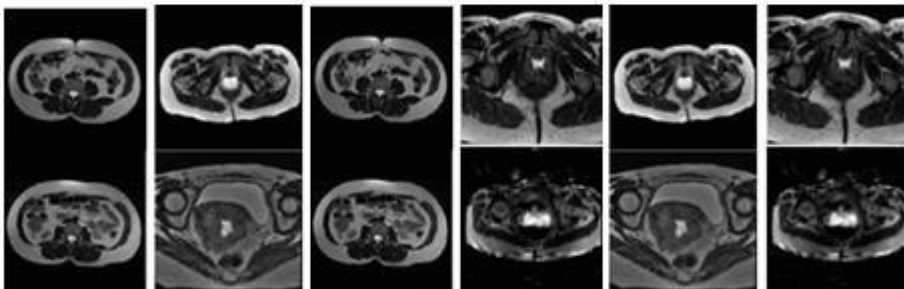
MRI cervix image data base
